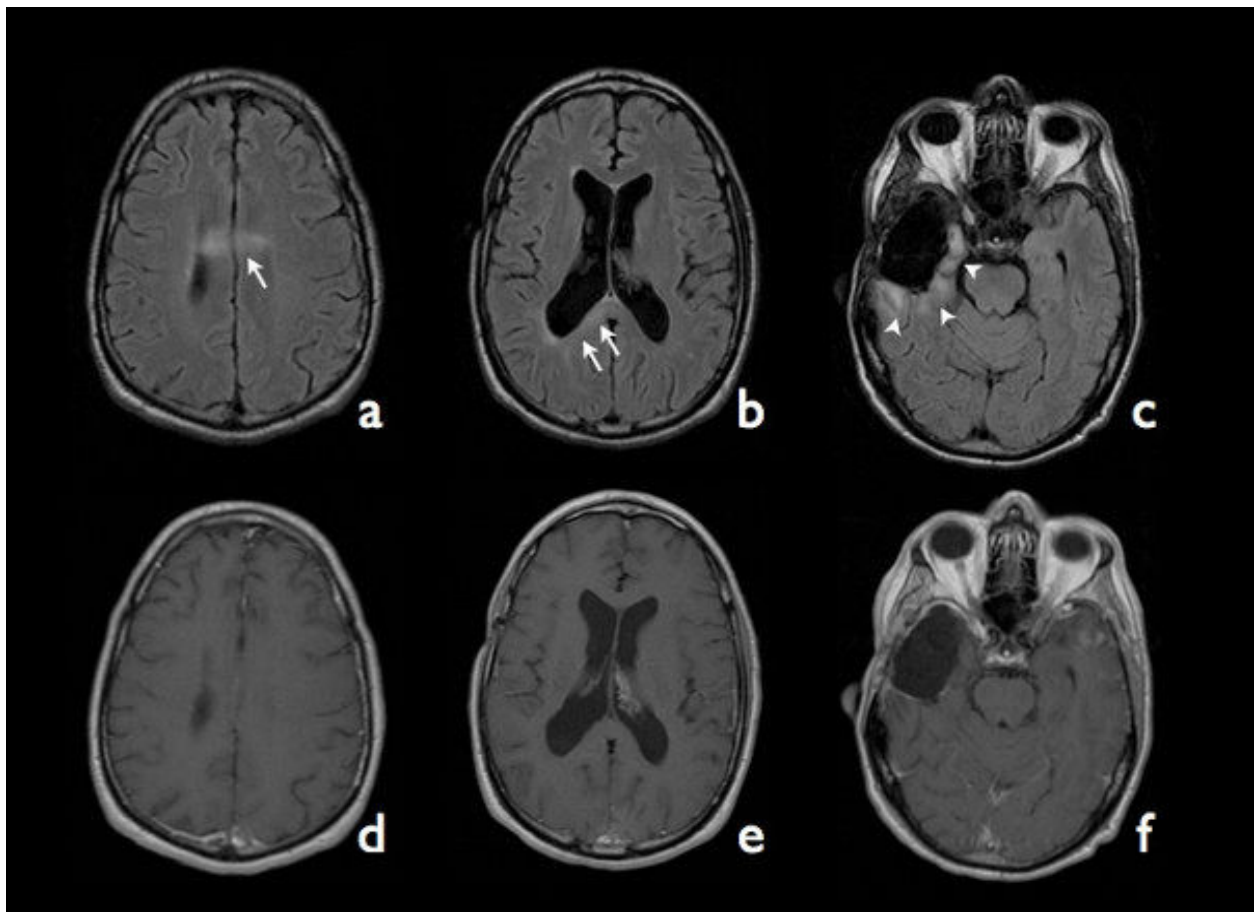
Six months after starting of bevacizumab treatment, FLAIR images (a, b, c) demonstrated two indistinct increased signals in the body and right aspect of the genu of corpus callosum (arrows) as well as diminished signal around the surgical cavity (arrowheads). None of the lesions were enhanced on post-contrast T1WI (d, e, f).
